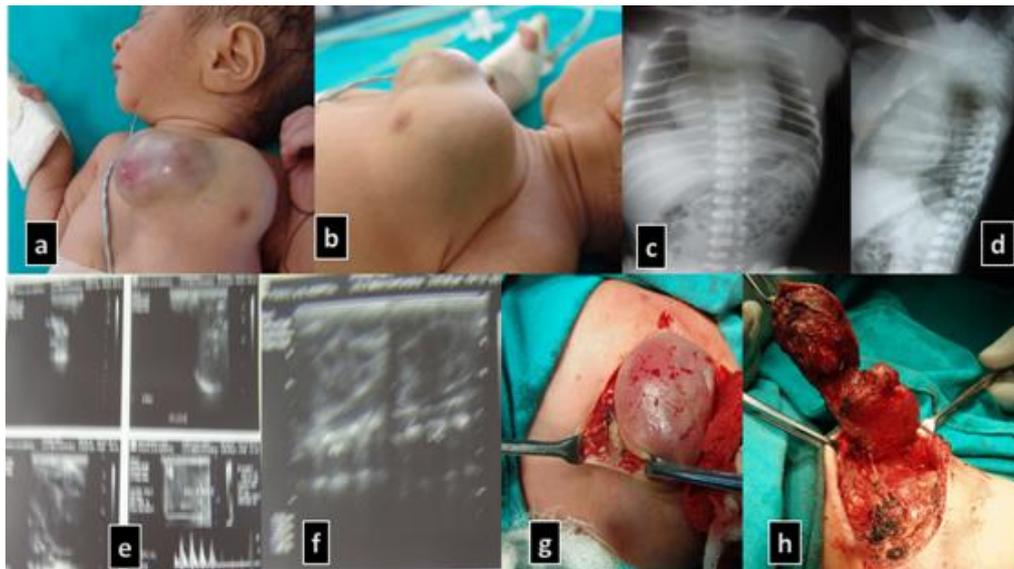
a) Clinical photograph showing tumor with localized redness and cutaneous telangiectasia, b) Photograph showing bi lobed nature, c) Chest radiograph showing soft tissue mass, normal lungs, d) Lateral radiograph showing mass without calcification, e) Ultra sonogram showing the mixed echoic lesion, f) Longitudinal USG and Doppler, g) Planned excision along with ellipse of skin, h) Showing a feeder vessel from inter costal artery
